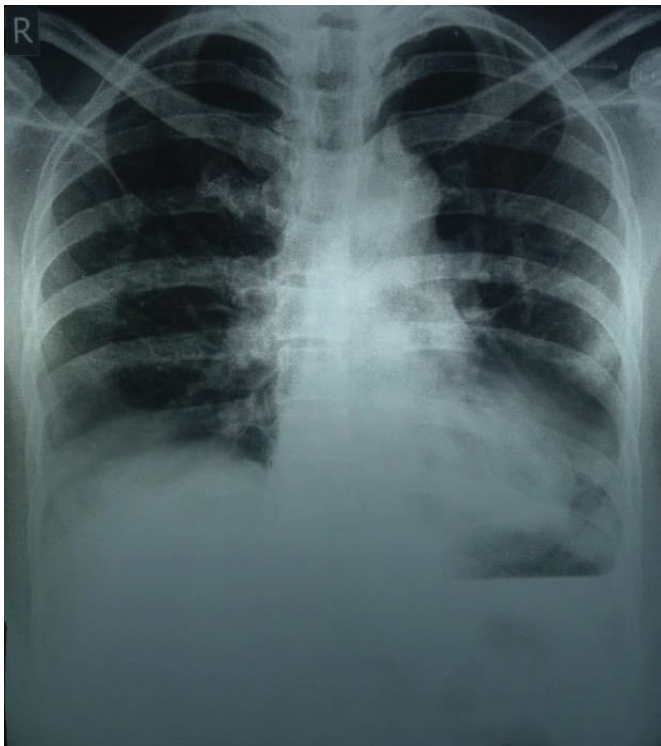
Chest X-ray examination showed an increase in bronchovascular pattern and slight opacity on the peripheral, basal part of both hemithorax
